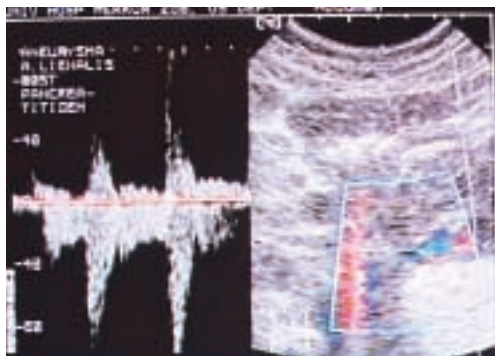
Pulsed-Doppler demonstrated bi-directional flow in aneurysmal neck and cavity; the communication with splenic artery was initially thought to exist.
